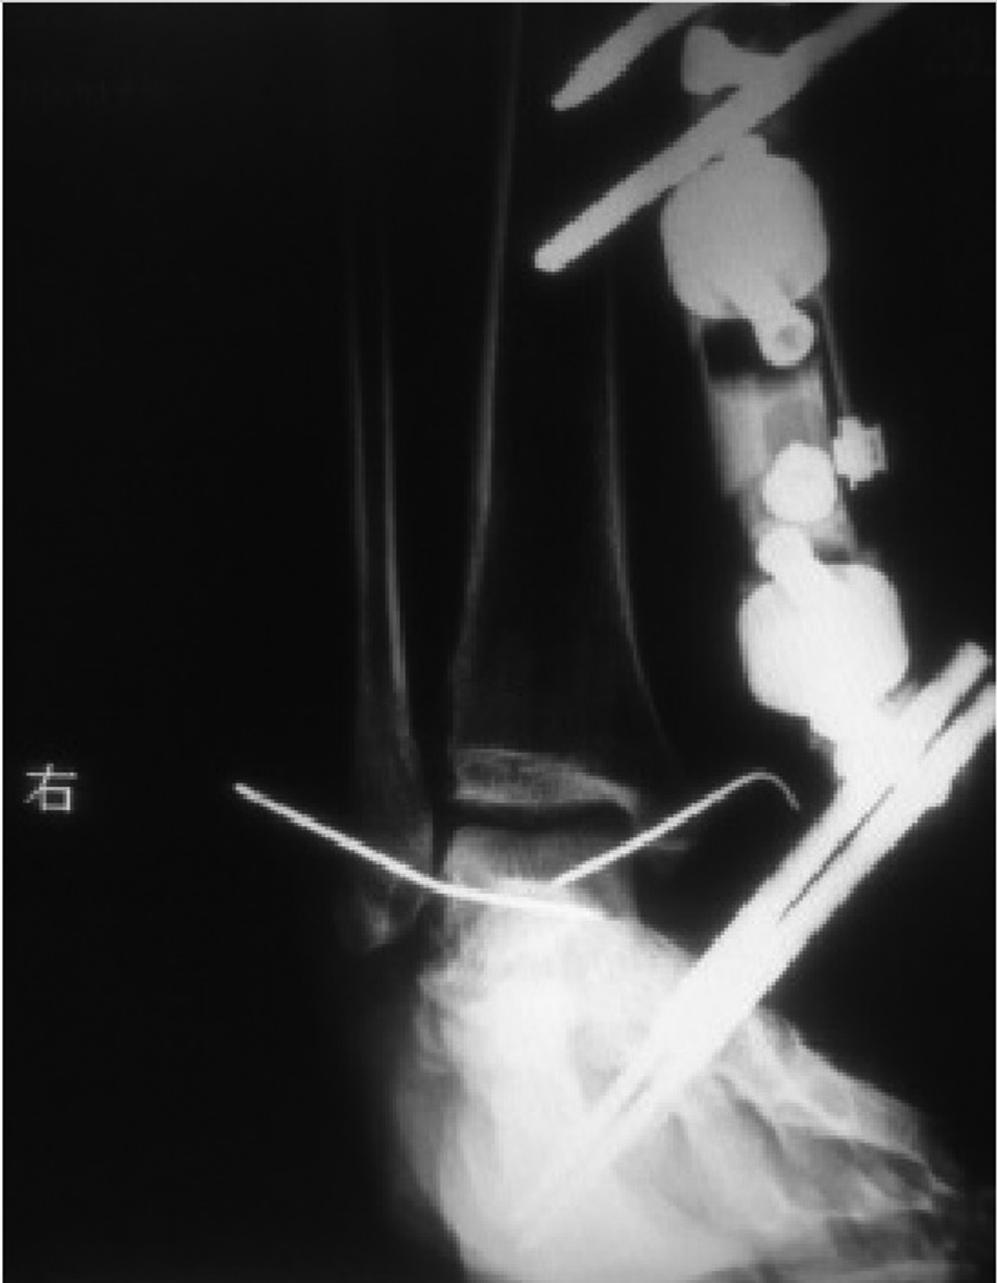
Anterior-posterior X-ray image of the ankle joint fixed with two K-wires and an external fixator.
